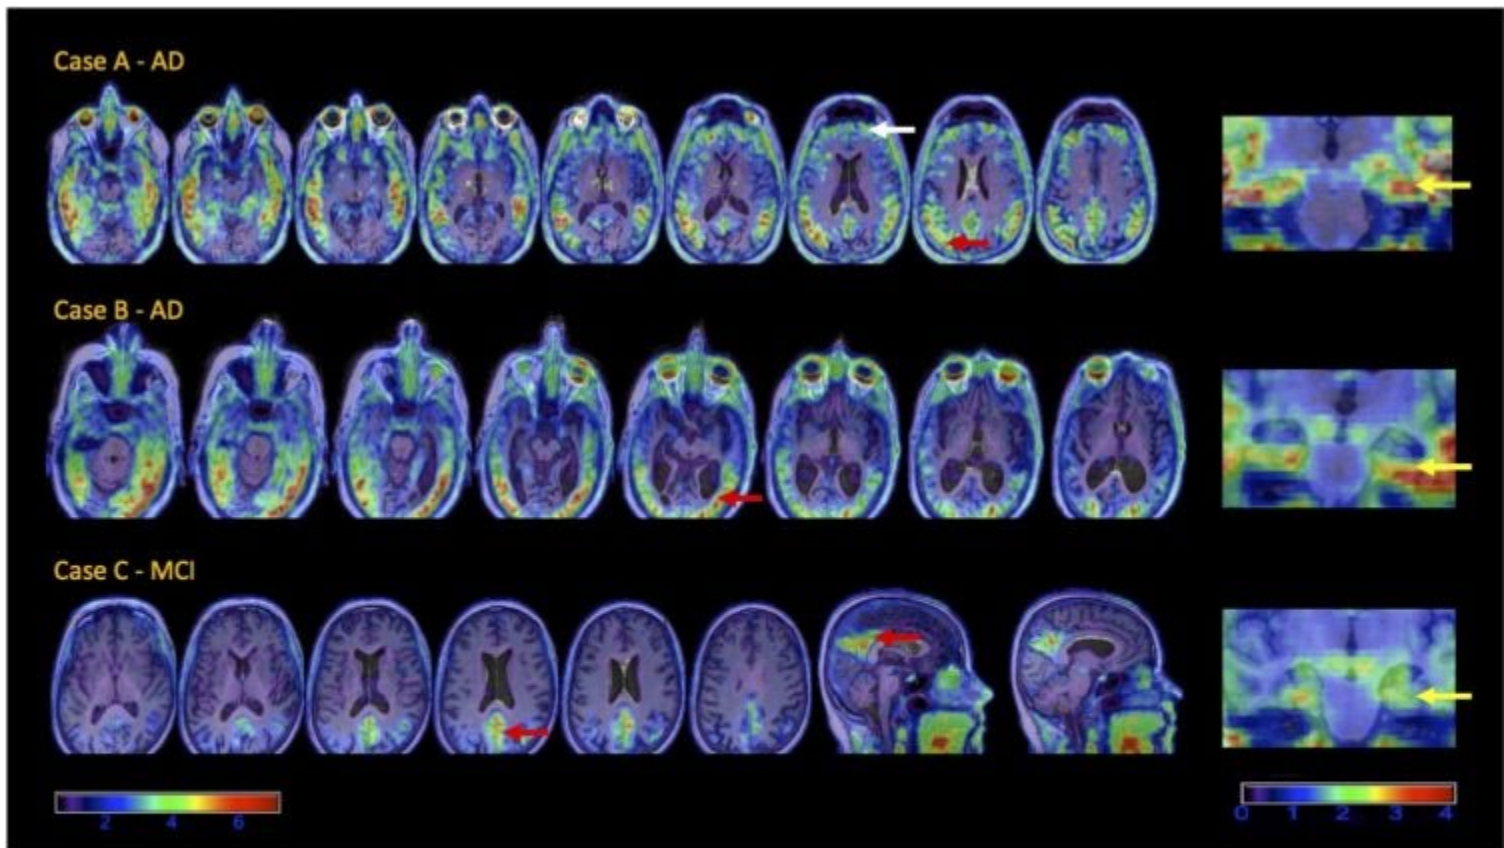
Representative tau PET slices for the three indeterminate cases using the F18-PI2620 Tau PET. Images are SUVRs, normalized by the inferior cerebellum. The scale for the axial and sagittal slices to the left ranges from SUVR values between 0-7, while the scale for the cropped coronal slices to the right ranges from 0-4. The early and predominant symptoms for the cases were as follows: Case A – dysexecutive, visuospatial; Case B – visuospatial, psychiatric; Case C – amnesic, visuospatial, dysexecutive. Tau tracer uptake generally aligned with clinical symptoms: the white arrow shows frontal involvement in Case A, in whom dysexecutive symptoms were prominent. Red arrows show prominent parieto-occipital involvement in all three cases, and visuospatial symptoms were prominent in all. In Case C, tracer uptake was generally more focal (red arrow), and significant frontal involvement was lacking despite dysexecutive symptoms, which could relate to this patient’s relatively milder symptoms (MCI rather than AD). Yellow arrows indicate that the medial temporal lobe was involved in all three cases, though similarly there was less avid uptake in Case C as compared to Cases A and B.
